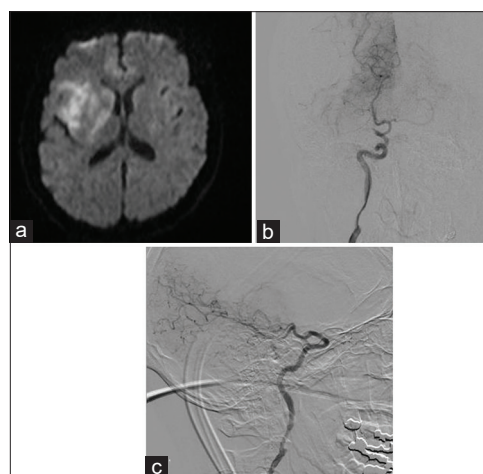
Diffusion-weighted image (DWI) and digital subtraction angiography. (a) DWI showed infarction of the posterior limb of the internal capsule, basal ganglia, and the insular and frontal cortices. (b and c) Digital subtraction angiography showed C7 narrowing and the superior-most aspect of the ICA occlusion.
